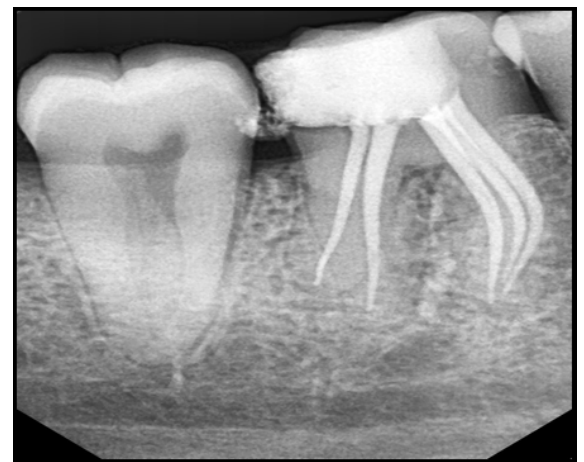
Post-obturation radiographs showing radix entomolaris & the middle mesial canal
